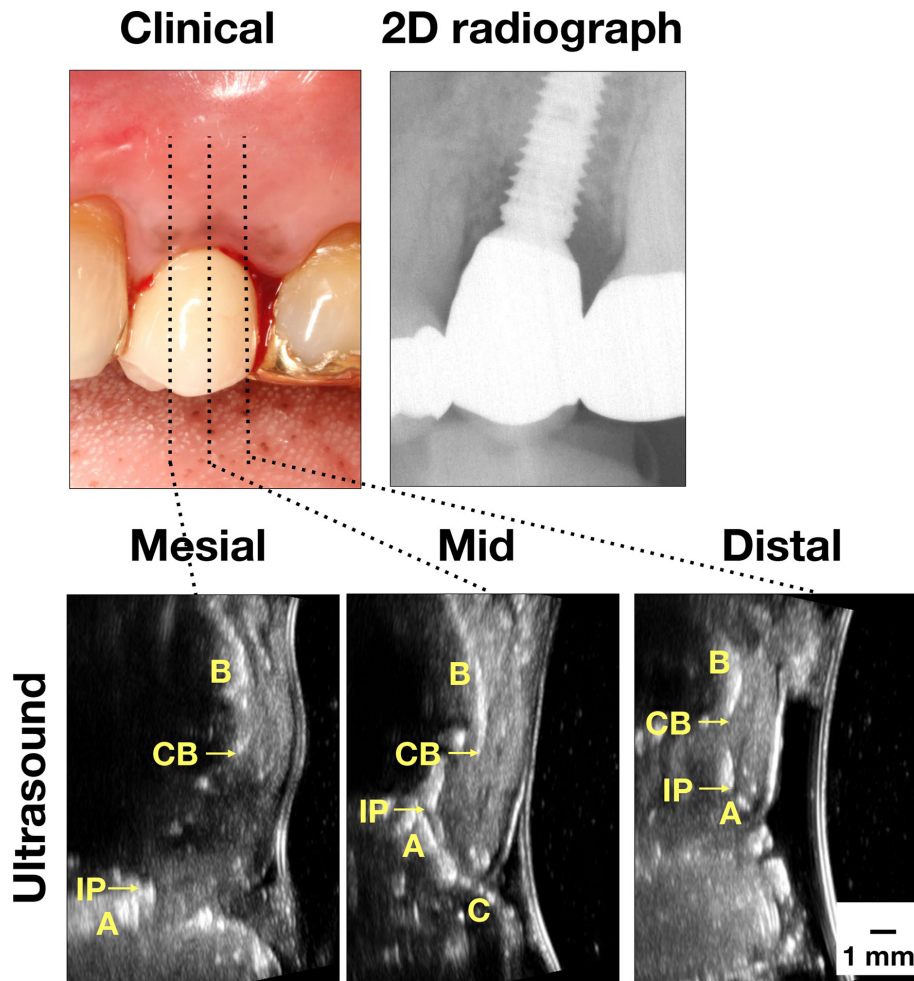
Case demonstration of an implant with peri-implantitis. Clinically, there were signs of inflammation, including bleeding on probing. Bone loss was obvious on the mesial site on the peri-apical film. Ultrasound images also showed bone loss. 2D, two-dimensional; A, abutment; B, bone; C, crown; CB, crestal bone; I, implant; IP, implant platform; M, mucosa; p, papilla).
